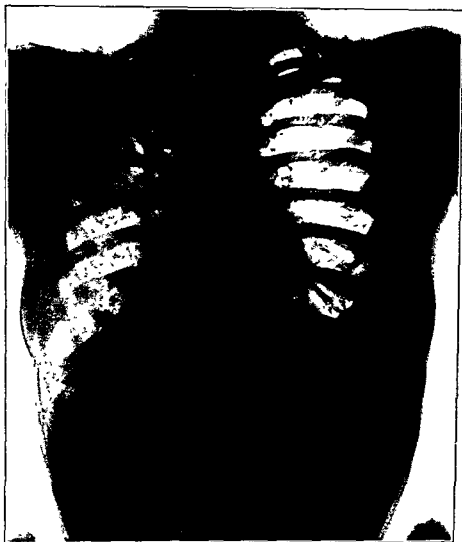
After consenting to go to a sanatorium the patient changed her mind because she felt so well. Fluoroscopy one month before this film showed the same appearance as Fig. 33. Four days before the present film pain was noted in left thorax. Temperature 104° F. Cough and expectoration. Physical examination and x-ray demonstrate an acute and extensive spread of the disease in the left lung.
